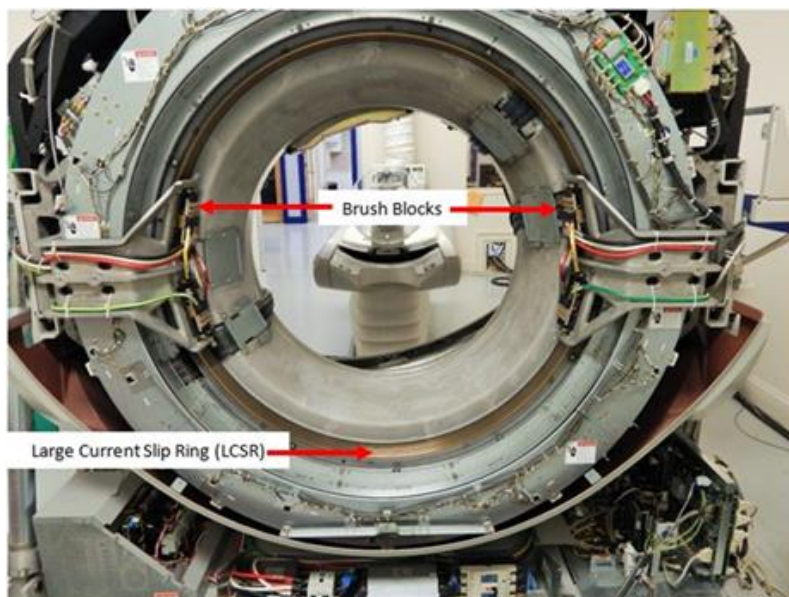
Slip Ring Technology used in 6th Generation CT Scanners.
